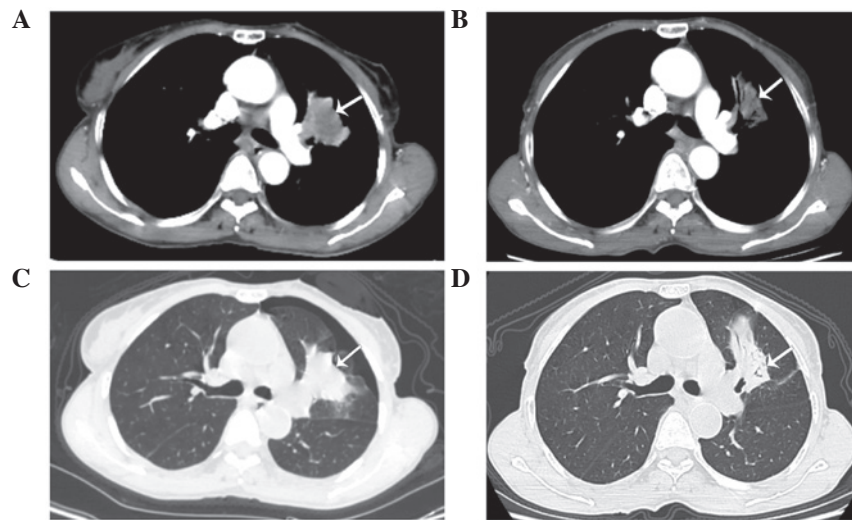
Chest computed tomography scans. Presence of a left upper lobe primary mass with multiple small pulmonary nodules in both lungs was observed prior to erlotinib treatment; a left upper lobe primary mass was identified on the (A) mediastinal window and (B) pulmonary window, respectively (arrows). Following 8 weeks of erlotinib treatment the mass had shrunk on the (C) mediastinal and (D) pulmonary windows, respectively (arrows).
